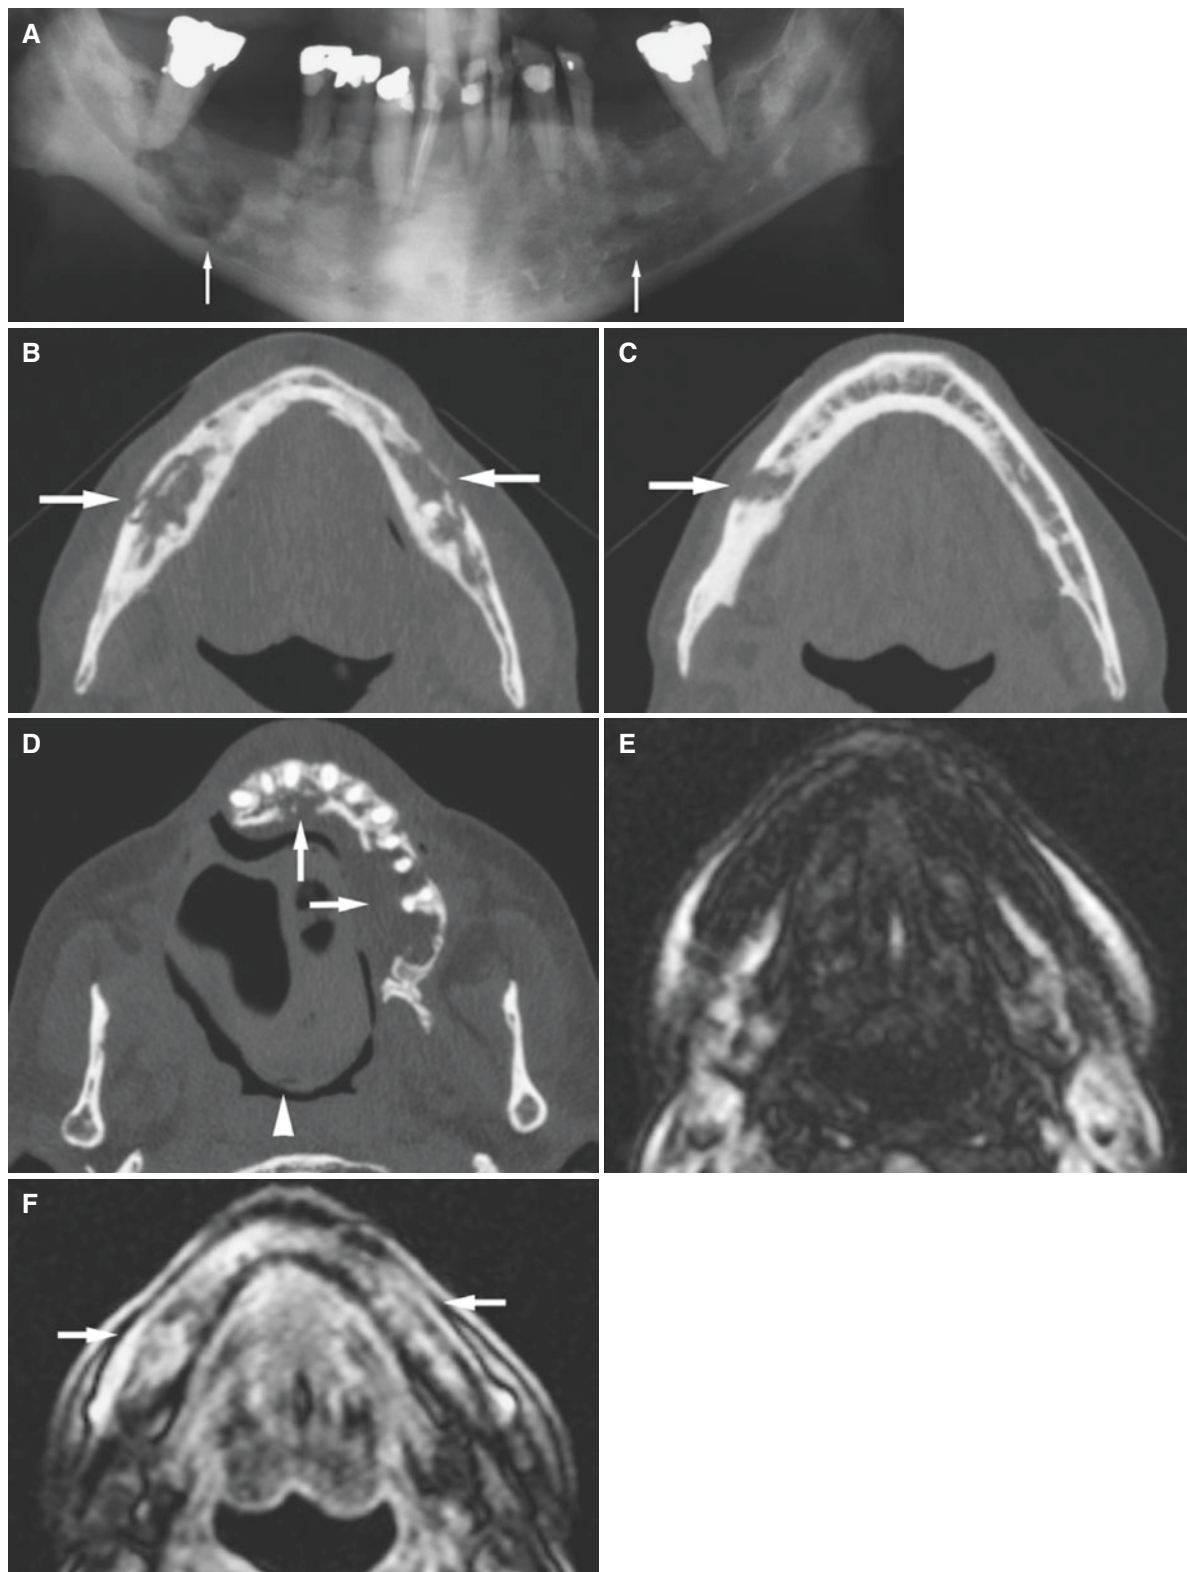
Osteoradionecrosis, mandible and maxilla; 55-year-old male 2 years after hemimaxillectomy and radiation therapy of adenoid cystic carcinoma. Denture could not be removed (see arrowhead in D). (A) Panoramic view shows destructive changes bilaterally (arrows). (B) Axial CT image shows evident bilateral destruction with sequestra (arrows). (C) Axial CT image shows more severe buccal destruction on
